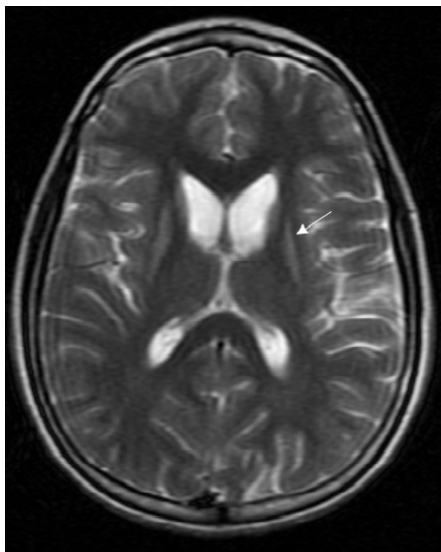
Axial T2-weighted image exhibits atrophy of bilaterally putamen (white arrow).
